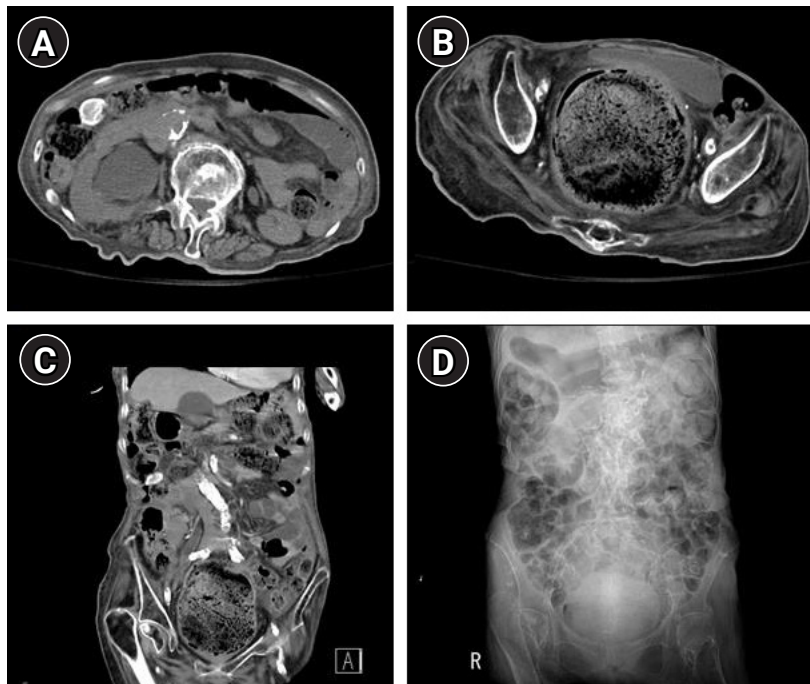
Hydroureteronephrosis caused by a giant fecaloma in the rectum. (A) Computed tomography (CT) of the abdomen-pelvis showing hydronephrosis in the right kidney. (B) CT of the abdomen-pelvis showing a huge distended rectum containing a giant fecaloma pushing the urinary bladder anteriorly and compressing the vesicoureteric junction. (C) CT of the abdomen-pelvis showing right hydronephrosis owing to a markedly dilated rectum caused by the huge fecaloma. (D) Giant fecaloma is visible in the kidney-ureter-bladder image.
